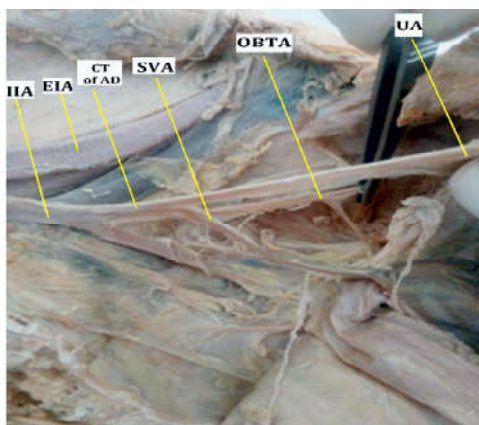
Showing the origin of Obturator Artery from Common Trunk of Anterior Division of Internal Iliac Artery (CT of AD)
